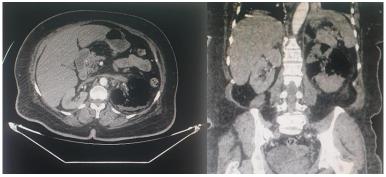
Abdominal CT scan in axial (A) and coronal (B) sections showing destruction of the left kidney with the presence of air in the left renal pelvis and diffusion of air into the retroperitoneal spaces in a 42-year-old patient with type 2 diabetes
